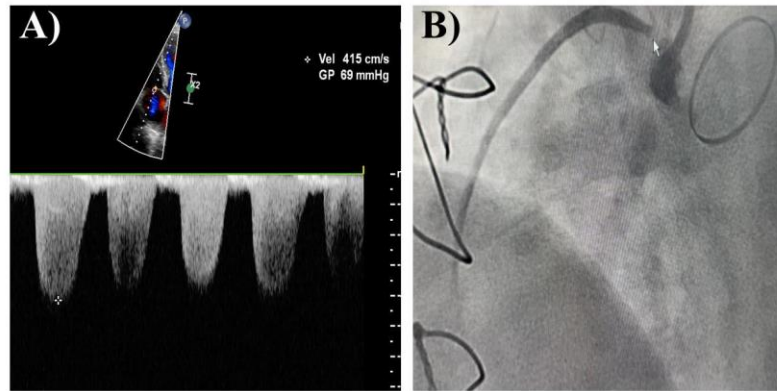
Echocardiogram showing elevated transprosthetic gradients. Figure 1B. Coronary angiography demonstrating occlusion of the right coronary artery.
